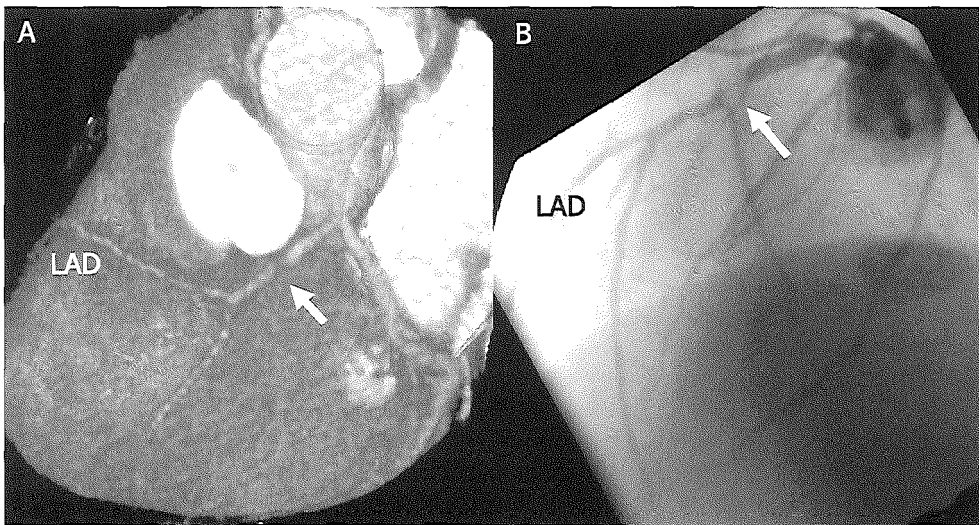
Electron beam CT coronary angiogram (A) and corresponding conventional angiogram (B), of a significantly stenosed (arrow) left anterior descending coronary artery (LAD).
